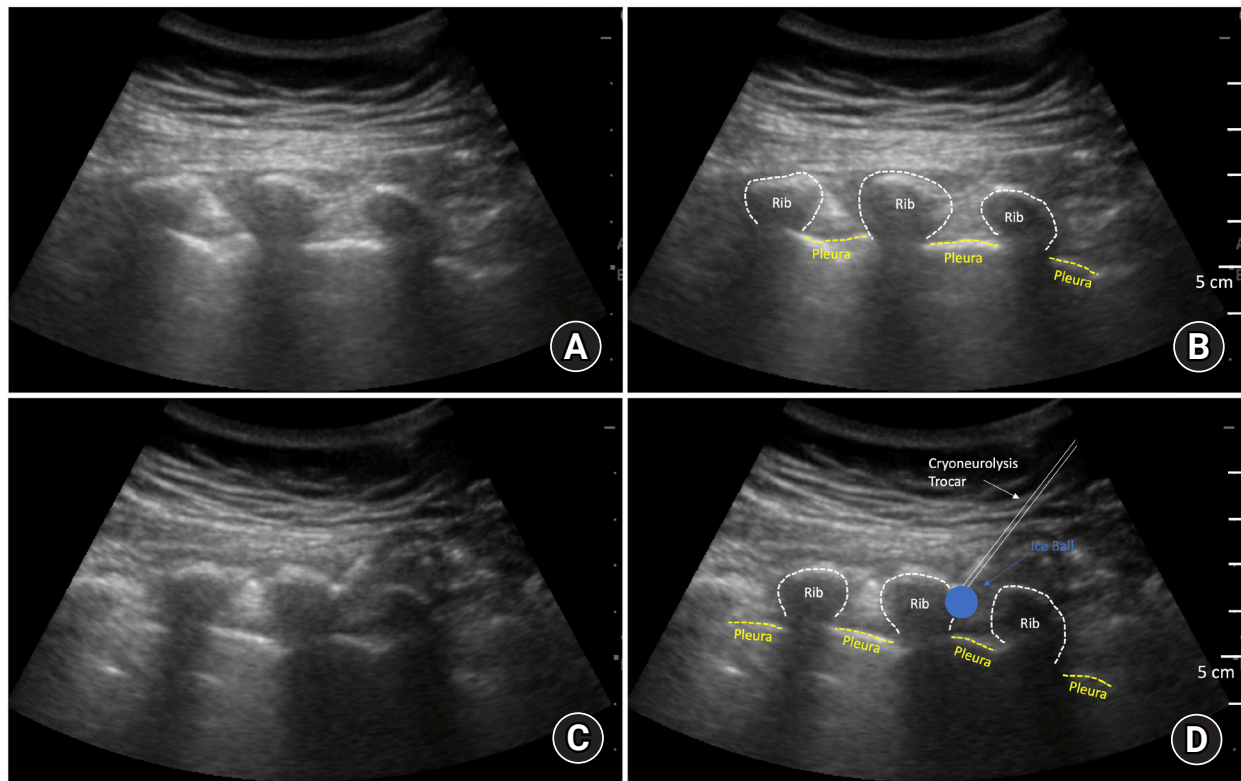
Ultrasound-guided percutaneous cryoneurolysis. (A) Parasagittal ultrasound view of T5–T8 intercostal nerves prior to cryoneurolysis, (B) Labeled anatomy of image A, (C) Parasagittal ultrasound view of cryoneurolysis of T7 intercostal nerve, (D) Labeled anatomy of image C. Cyan circle indicates area of ice ball created from cryoneurolysis, white line: trajectory of cryoneurolysis probe.
